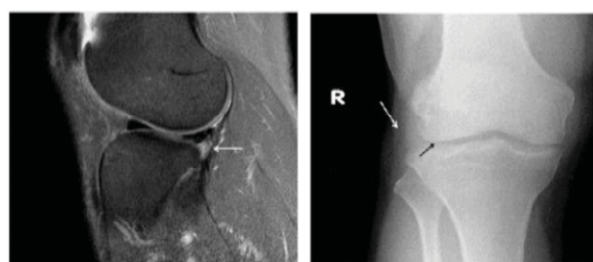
(a) MRI of 26 year old male patient showing grade III tear of lateral meniscus posterior horn (arrow) Fig. 2(b) The plain radiograph of 26 year old male patient showing grade III tear of lateral meniscus posterior horn on the MRI (Fig. 4(a)) shows decreased lateral tibio femoral joint space (black arrow), with indistinct lateral fat planes (white arrow)
